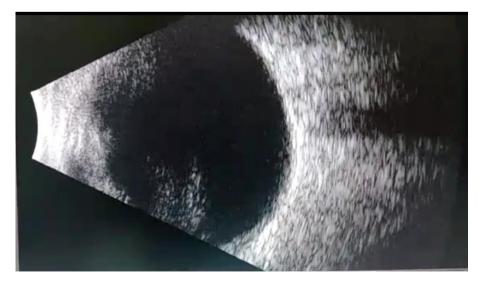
B-mode ultrasound
